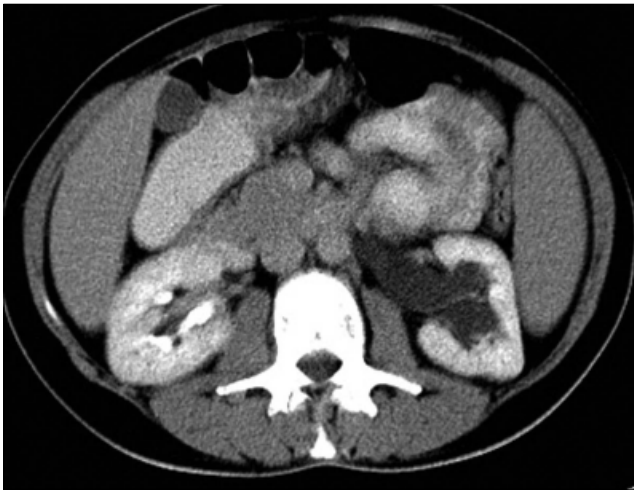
On axial CT imaging after contrast media administration, there is left side hydronephrosis due to distal ureteral obstruction.
